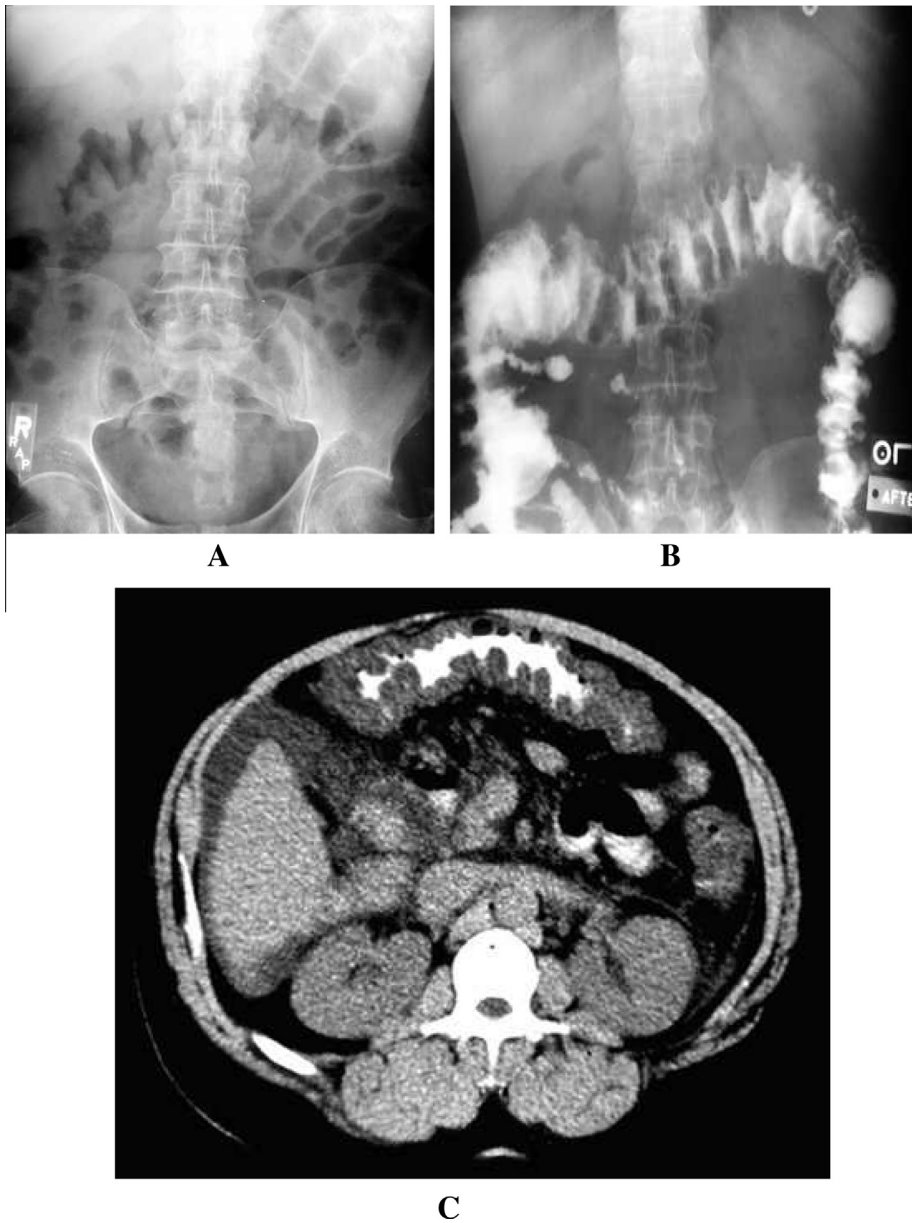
(A) Frontal abdominal radiograph showing nodular haustral thickening, (B) Barium enema showing serrated appearance of transverse colon and (C) CT scan showing the classic accordion sign of pseudomembranous colitis (52).
